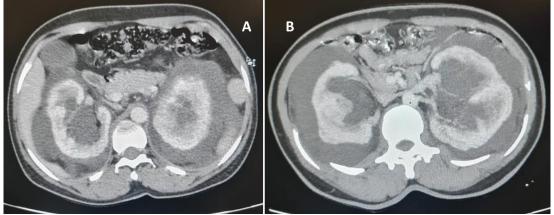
(A and B): Abdominal CT with axial reconstruction and MIP on both kidneys showing the appearance of hairy kidneys
